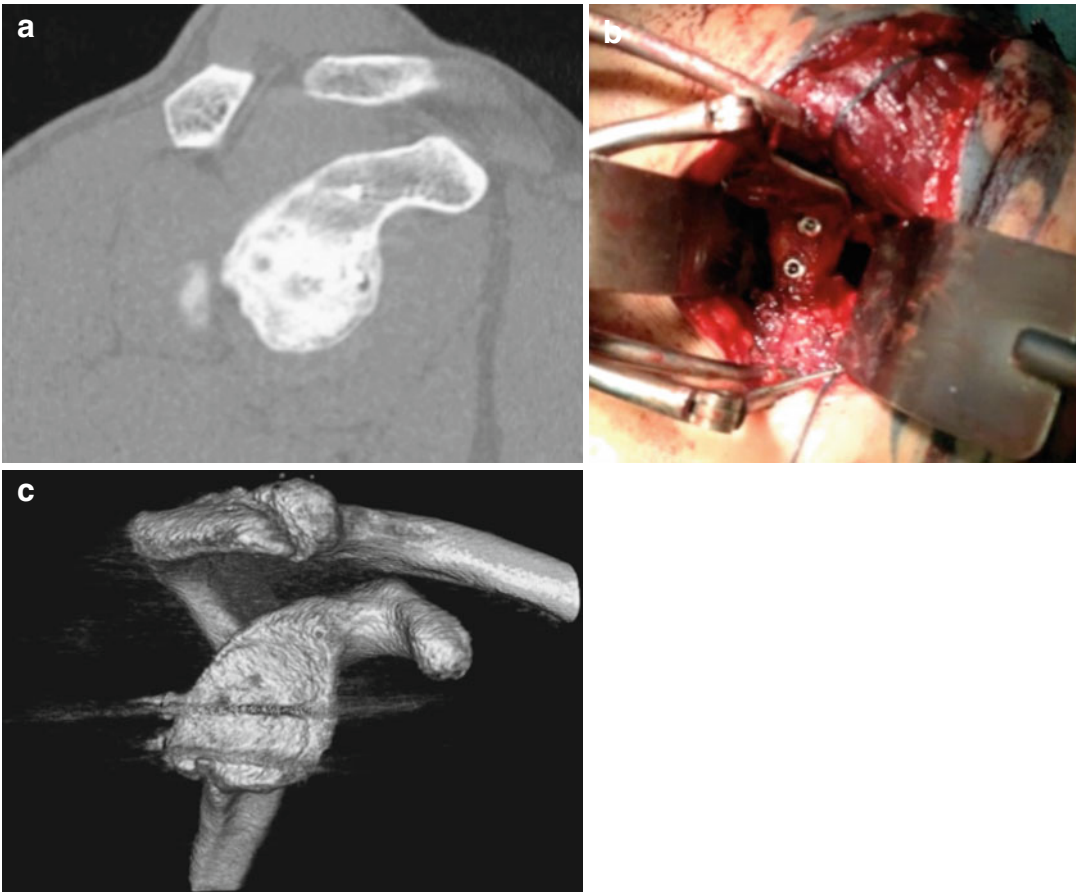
Posterior bone-block procedure. Preoperative CT scan of glenoid in sagittal plane (a). Open posterior bone-block procedure through posterior approach to the shoulder (b). CT scan – 3D reconstruction image after the surgical procedure (c)
